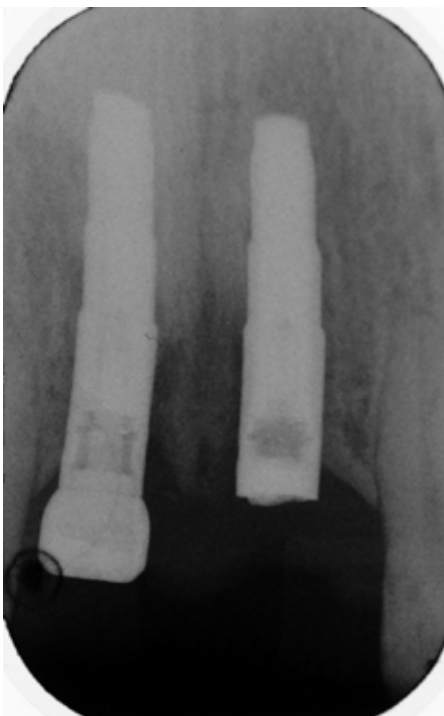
(a) Radiograph of two implants (UR1 and UL1) with healing abutment *in situ* on UR1 and screw fragment evident in UL1. (b) Retrieved apical fragment of fractured screw from UL1 implant.
